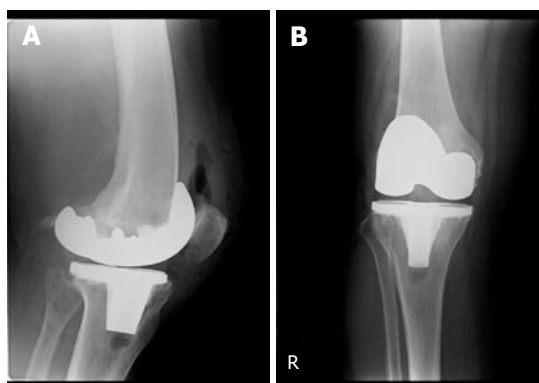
Immediate postoperative X-rays of the total knee replacement in recovery (A and B).
